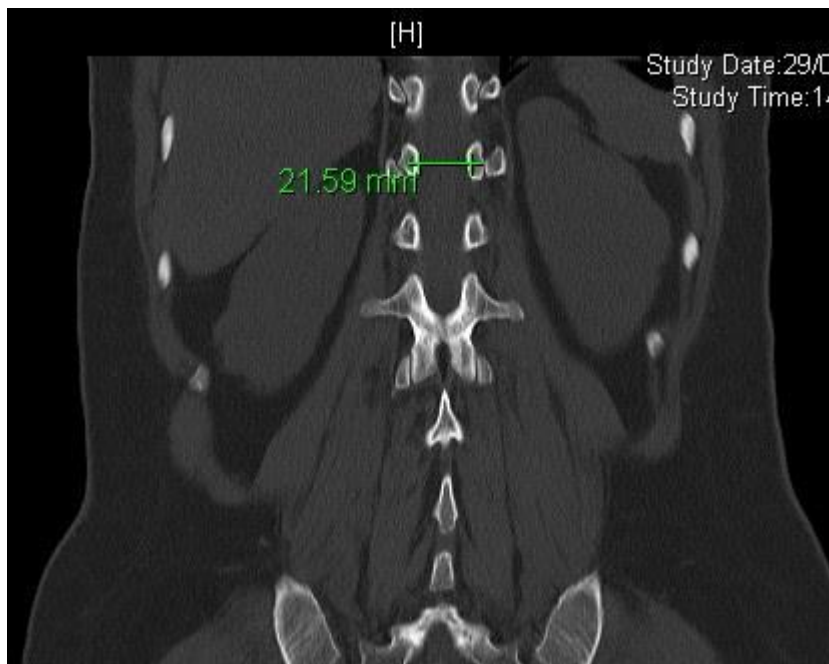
Image showing Inter Pars distance on CT:
